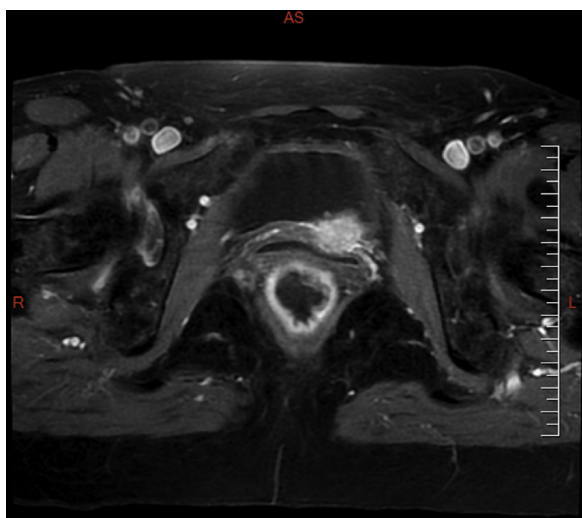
A 3 cm lesion between vagina and bladder on pelvic MRI.
